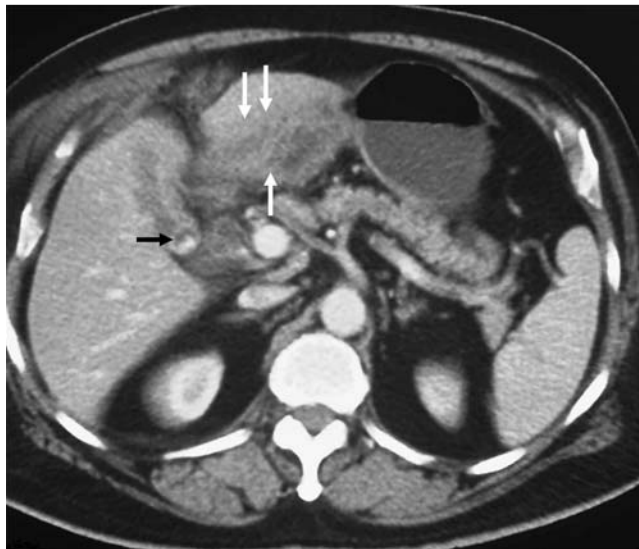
Contrast-enhanced computed tomography (CECT) abdomen showing thickening of the antral wall (white arrows) and gallbladder stone (black arrow).
